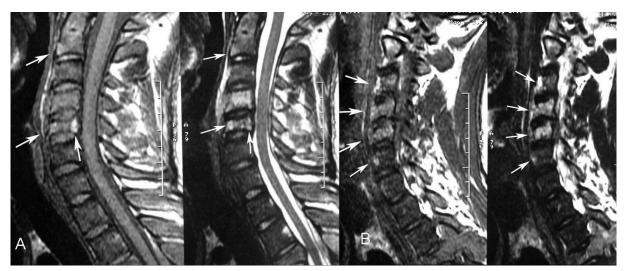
A-B: At sagittal MR images multiple lesions with intermediate- and high signal intensty on T1-weighted images (left), high-signal intensity on T2-weighted images (right) were seen in many cervical vertebrae (white arrows).
